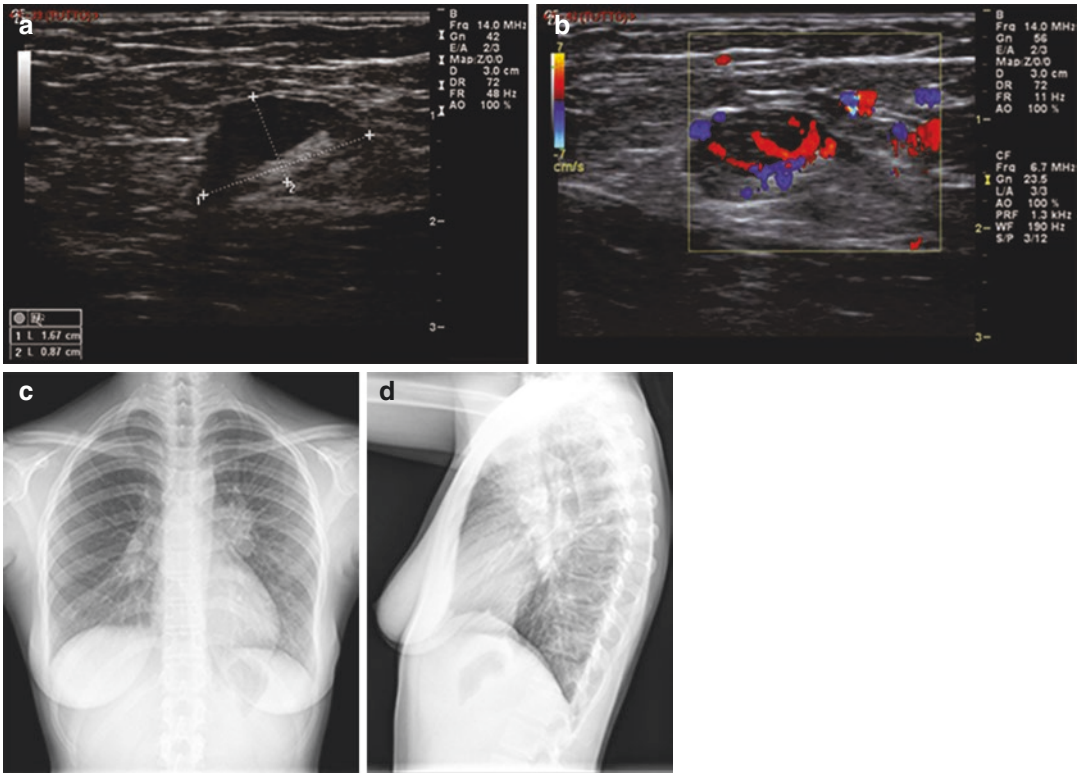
Ultrasound of axillary lymph node in a young patient with non-Hodgkin's Lymphoma (a, b). Evident roundish morphology and vascularization accentuated
